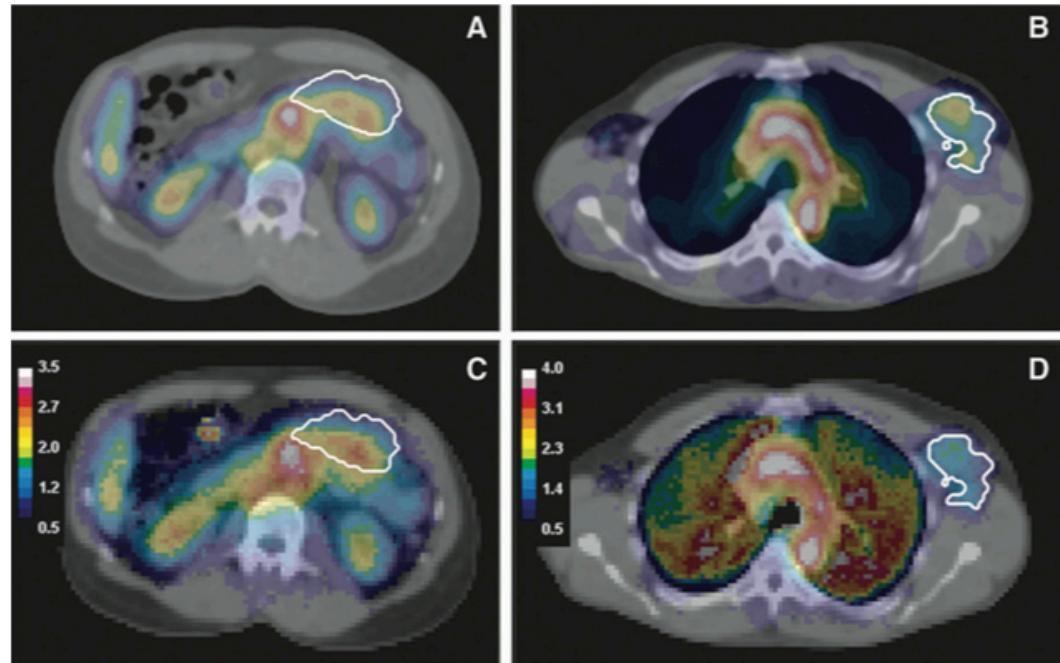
Fused SPECT/CT images for patient 1 (A) and patient 2 (B) with matching 3D dose maps overlaid on CT for patient 1 (C) and patient 2 (D). The dose maps are displayed in units of Gy. Color images available online at www.liebertpub.com/cbr
